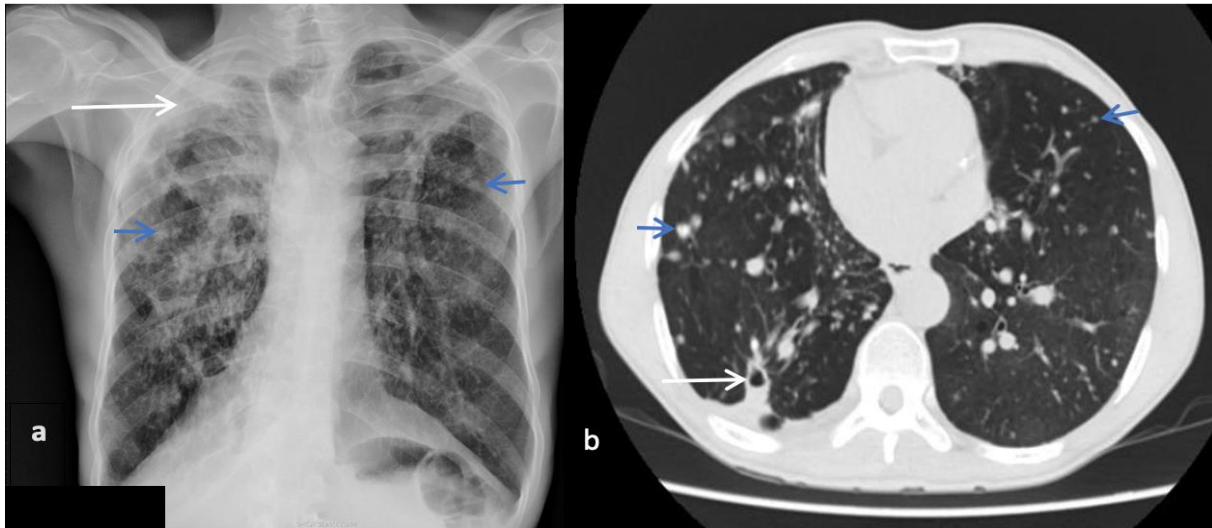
a. Plain frontal radiograph of another CPA patient, demonstrates bilateral apical lung fibrosis with associated hilar retraction and distortion. Right apical pleural thickening (long white arrow) and adjacent consolidation. Background of diffuse bilateral lung nodules (short arrows). b. Corresponding Axial Chest CT scan- lung window demonstrates a small right lower lobe superior segment cavity, which was not demonstrated on the plain radiograph and multiple bilateral lung nodules (short blue arrows)
